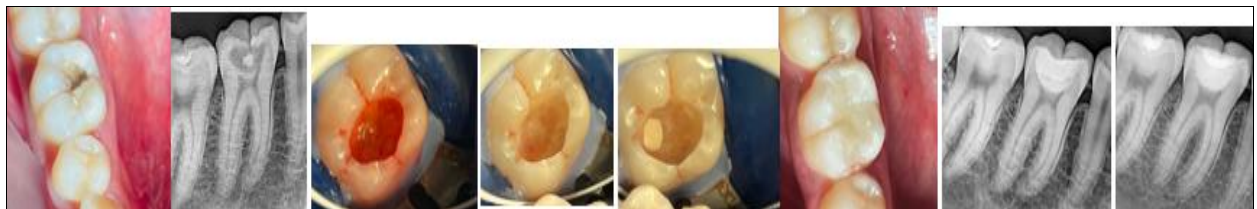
Clinical and radiographic sequence for Case 3: preoperative assessment, caries detection, pinpoint pulp exposure, MTA placement, immediate postoperative restoration, and 12-month follow-up.
